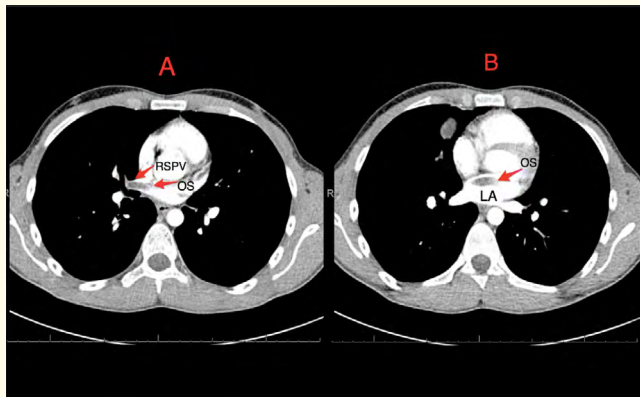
(A&B): Computed tomography (CT) scan showing invasion of the osteosarcoma, with (A) displaying the mass entering the left atrium through the right superior pulmonary vein; and (B) showing the mass in the left atrium. LA, Left Atrium; OS, Osteosarcoma; RSPV, Right Superior Pulmonary Vein.
